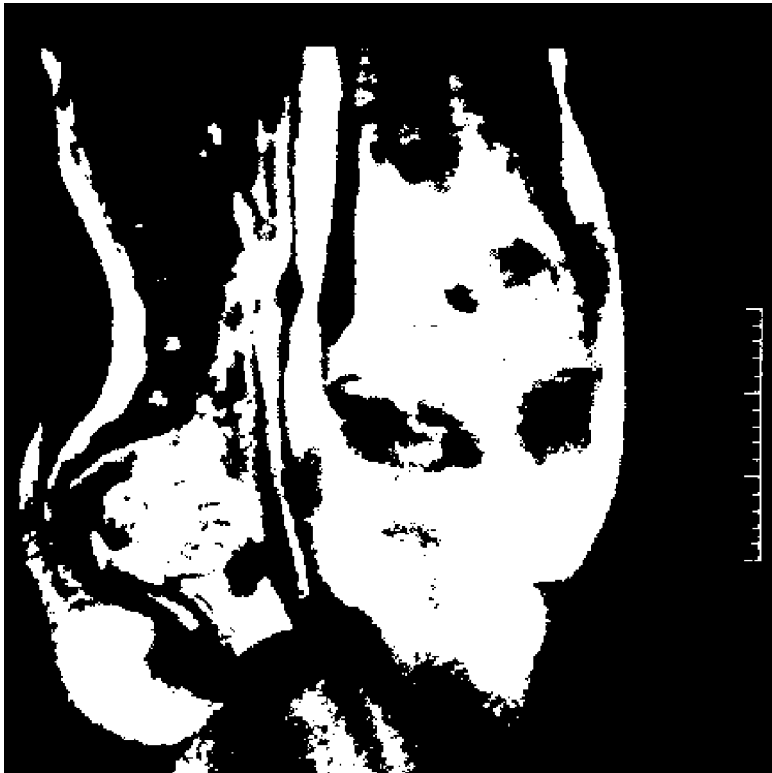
MRI first session without penetration
